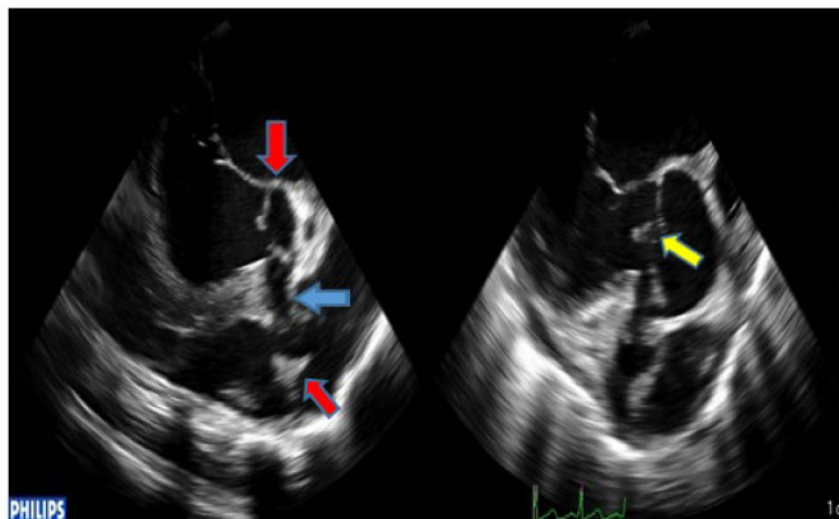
Long-axis transoesophageal views showing destruction of aortic and pulmonary valve leaflets (red arrows) and fistula (blue arrow) with superimposed vegetations (yellow arrow).
